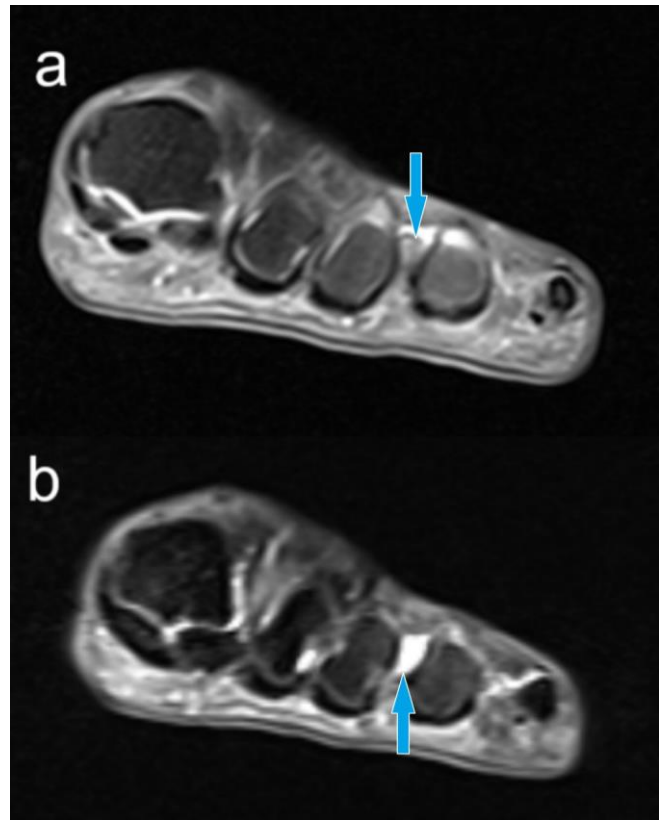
a) T1 MR image, b) T2 MR image of Morton's neuroma located between the 3rd and 4rd metatarsal heads of the patient's foot (arrow).
